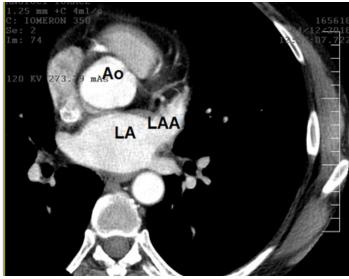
Computed tomography of the heart. The left atrial appendage is an anterior and lateral structure.
